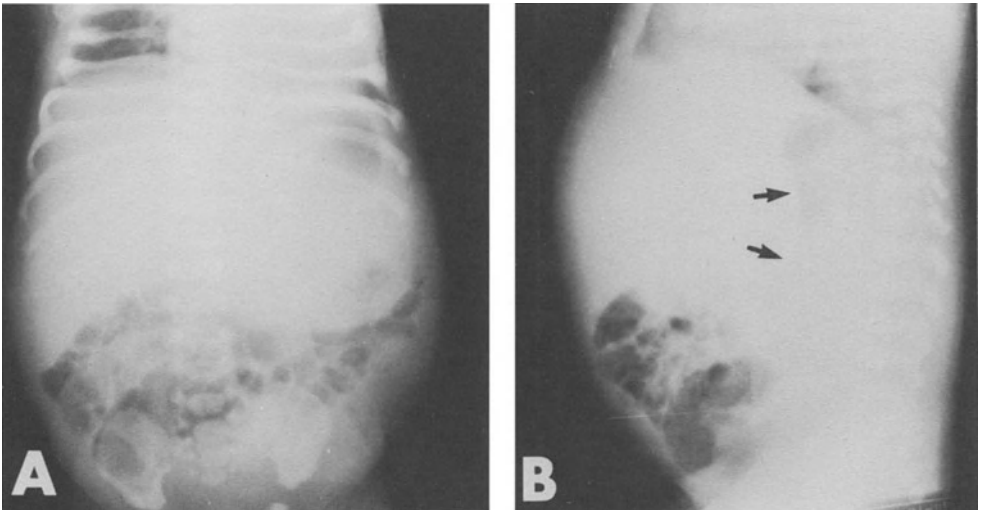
A. Anteroposterior and B. Lateral radiographs of a neonate with a left upper quadrant and flank mass. The frontal view shows inferior displacement of the distal transverse colon. The lateral view demonstrates posterior displacement of the gastric air bubble (arrows) and, therefore, excludes retroperitoneal origin of the mass. The mass was proven to be a hemangioendothelioma of the left lobe of the liver.
